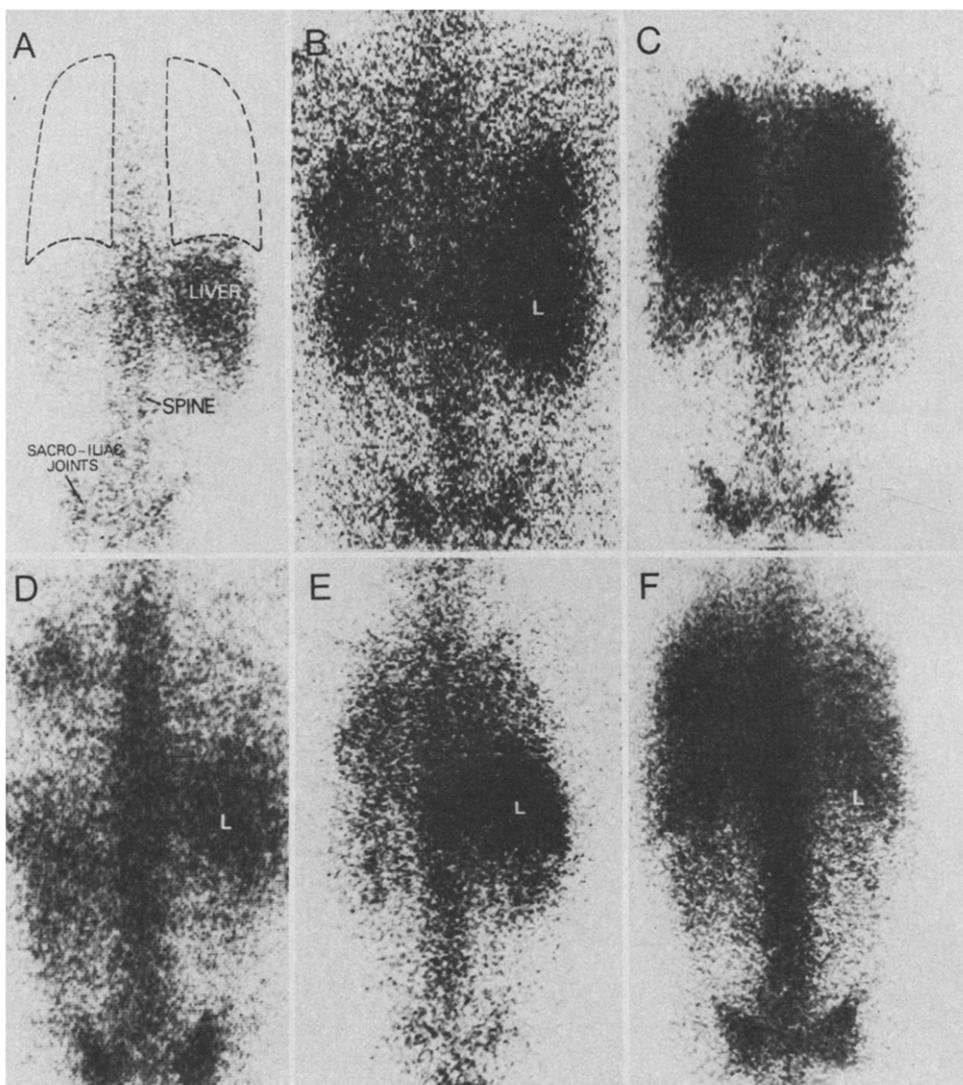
Posterior thorax and abdominal gallium-67 rectilinear scans from a normal patient and five patients with interstitial lung disease. A, normal person showing physiologic accumulation of gallium-67 in spine, pelvis, liver (L) and spleen. Low intensity uptake in lower lung fields is associated with rib localization. B, gallium-67 scan of uptake in 45 year old white man with silicosis. Diffuse uptake in the lower part of the lung is associated with more intense accumulations in lateral basal lung regions (^{67}Ga -index = 135 U). C, diffuse, high intensity lung uptake in 56 year old white woman with bleomycin lung toxicity. Pulmonary localization is more intense than hepatic uptake (^{67}Ga -index = 360 U). D, thirty-five year old white man with Wegener's granulomatosis showing focal uptake in the upper lobe of the left lung and diffuse uptake in the lower lobe of the right lung (^{67}Ga -index = 55 U). Focal uptake corresponds to pulmonary infiltrate with cavitation on the chest roentgenogram. Two older cavities in right lung did not localize gallium-67. E, gallium-67 scan of a 55 year old white woman with idiopathic pulmonary fibrosis. Diffuse uptake of moderate intensity in the mid and lower lung zone with no focal prominence (^{67}Ga -index = 155 U). F, diffuse gallium-67 uptake with prominence of right mid lung in 28 year old black man with sarcoidosis (^{67}Ga -index = 220).
